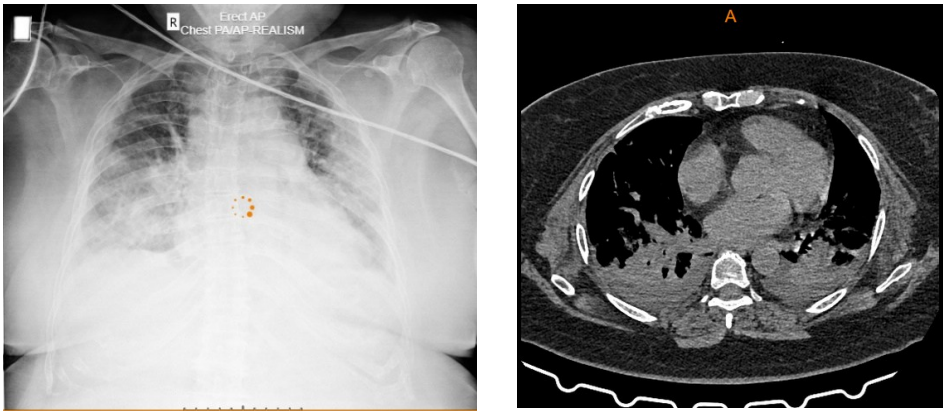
Chest Xray and CT Scan on Day 1: Posterior lung consolidation on patient's CT and EIT images
